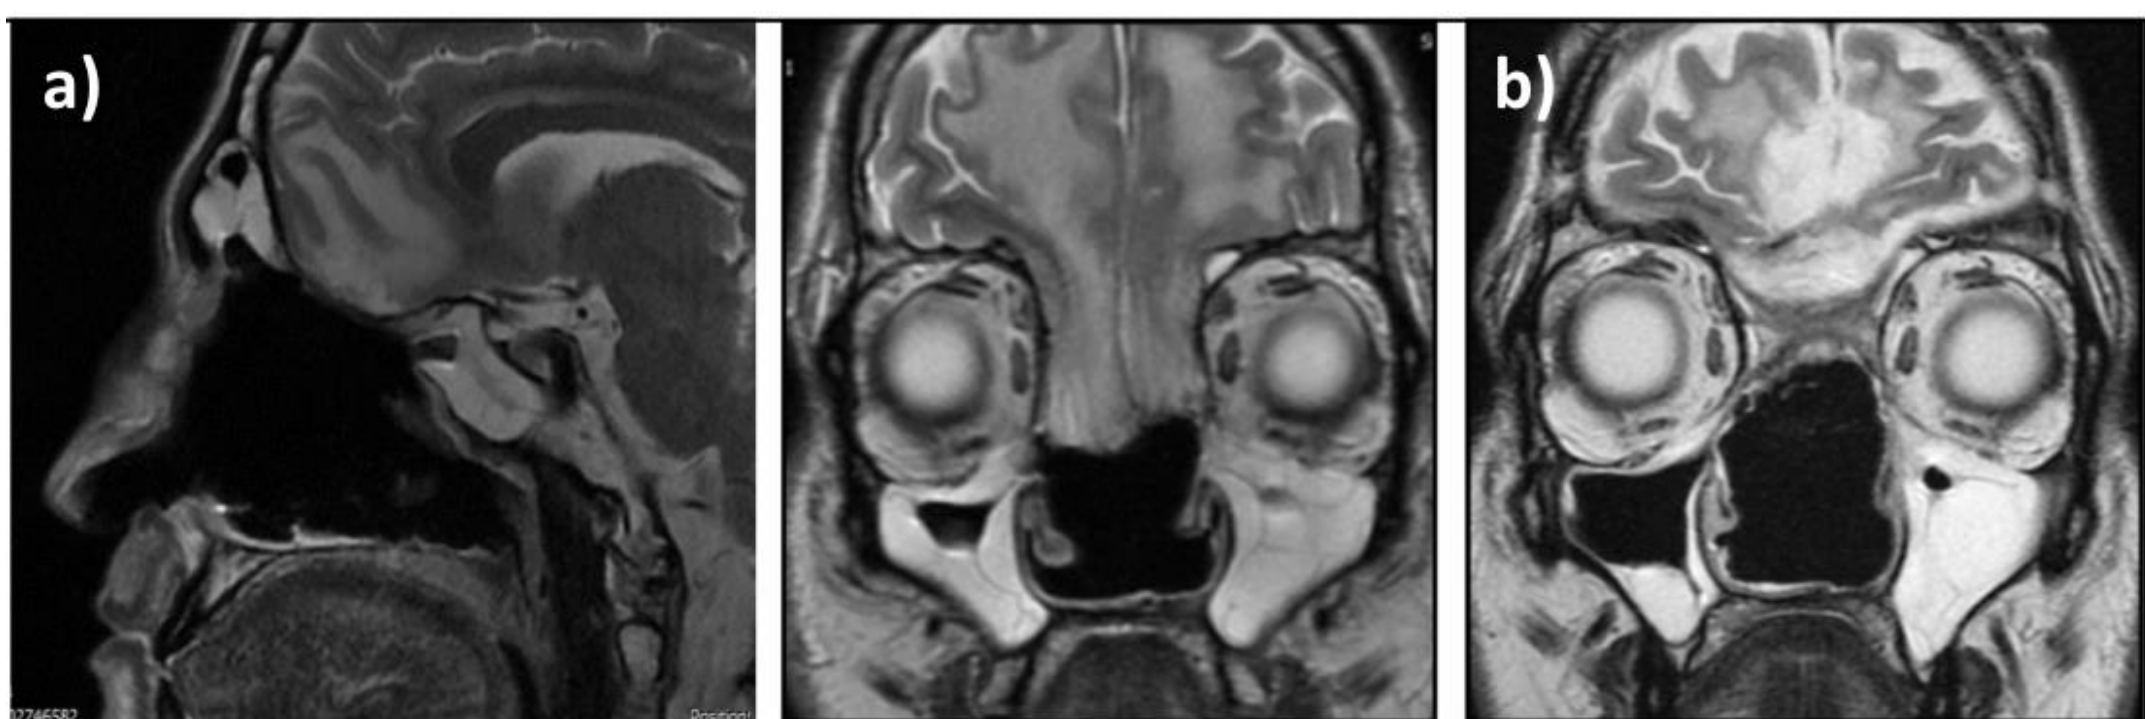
a) RT induced frontal encephalocele. b) Post-operative repair MRI.
